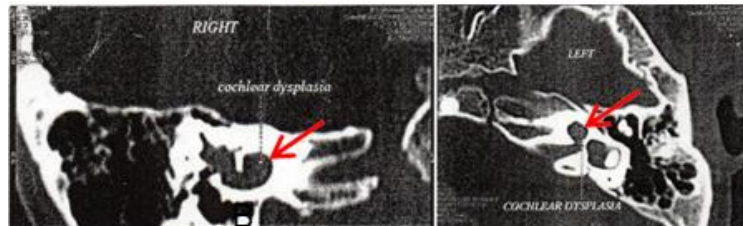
The result of CT scan of patient in case 1.
